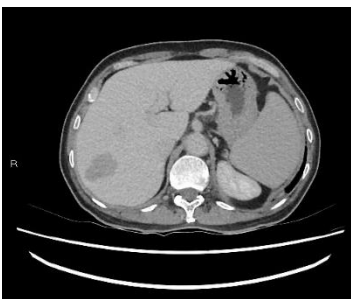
Delayed phase of contrasted computed tomography scan of the liver, the lesion in segment VII remains hypodense relative to liver.
